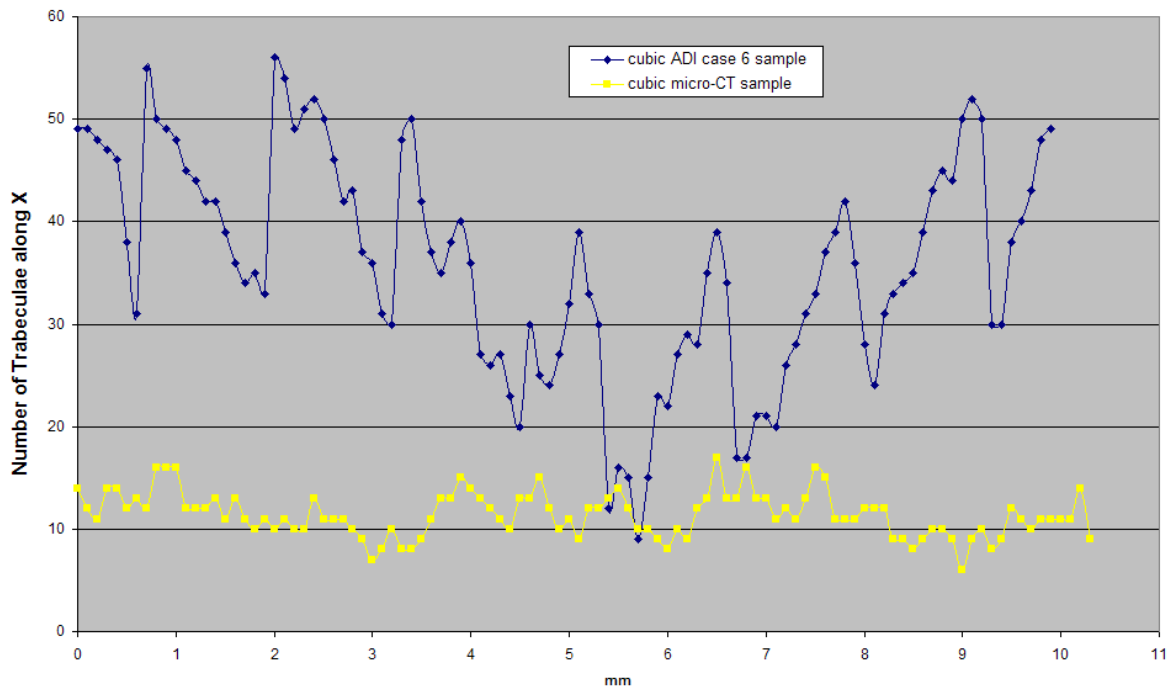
Comparison of trabecular area along  $X$  between the cubic ADI case 6 sample and cubic  $\mu$ CT sample
